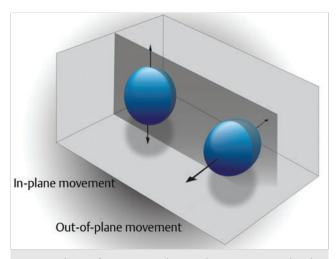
When performing strain elastography, it is important that the same image plane through a lesion be maintained during data acquisition. The dark gray plane corresponds to the ultrasound beam. An optimal elastogram is obtained with only in-plane movement of the lesion. Out-of-plane movement may result in inaccurate elastography results.
